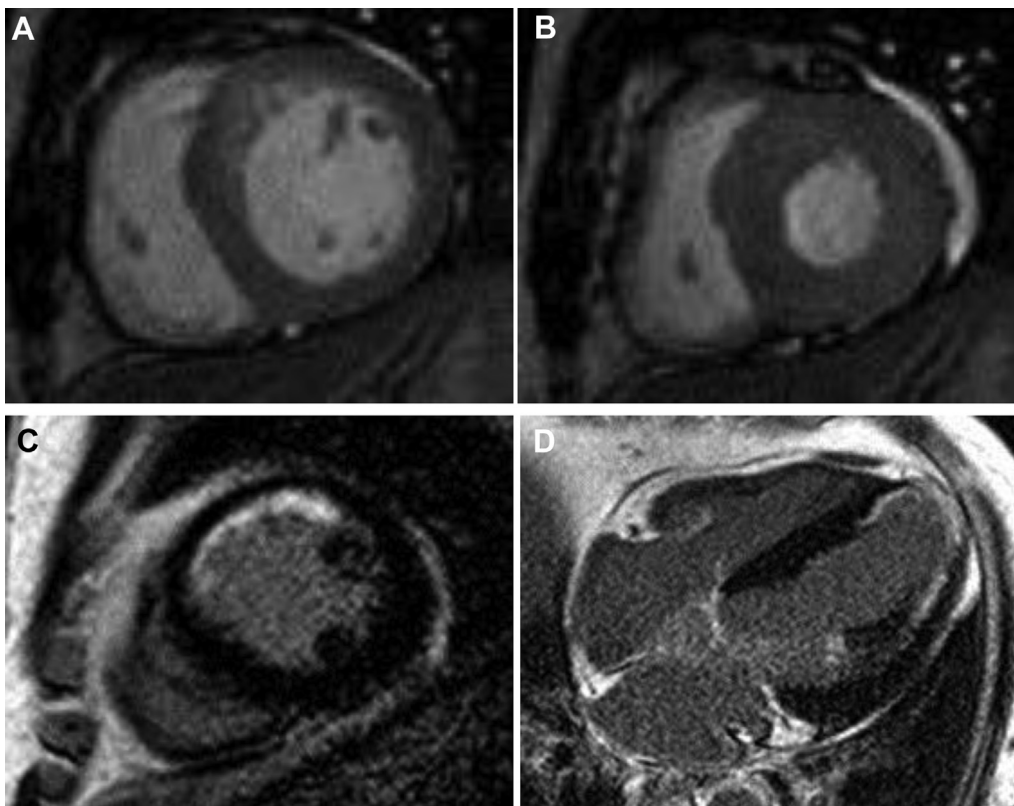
Magnetic resonance images of the left ventricle in a 58-year-old man with 3-vessel disease. Cine-MRI obtained in (A) diastole and (B) systole showing LVEF of 60%. (C, D) LGE-MRI showing myocardial infarction in the left anterior descending artery territory, with an LGE extent of 9.8%.
